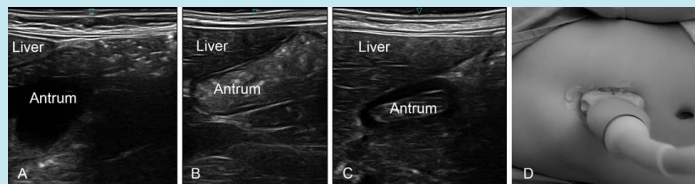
Sonographic images of the antrum filled with clear fluid (A), with solid contents (B) and empty (C), transducer position to scan the gastric antrum in the right lateral position (D).
